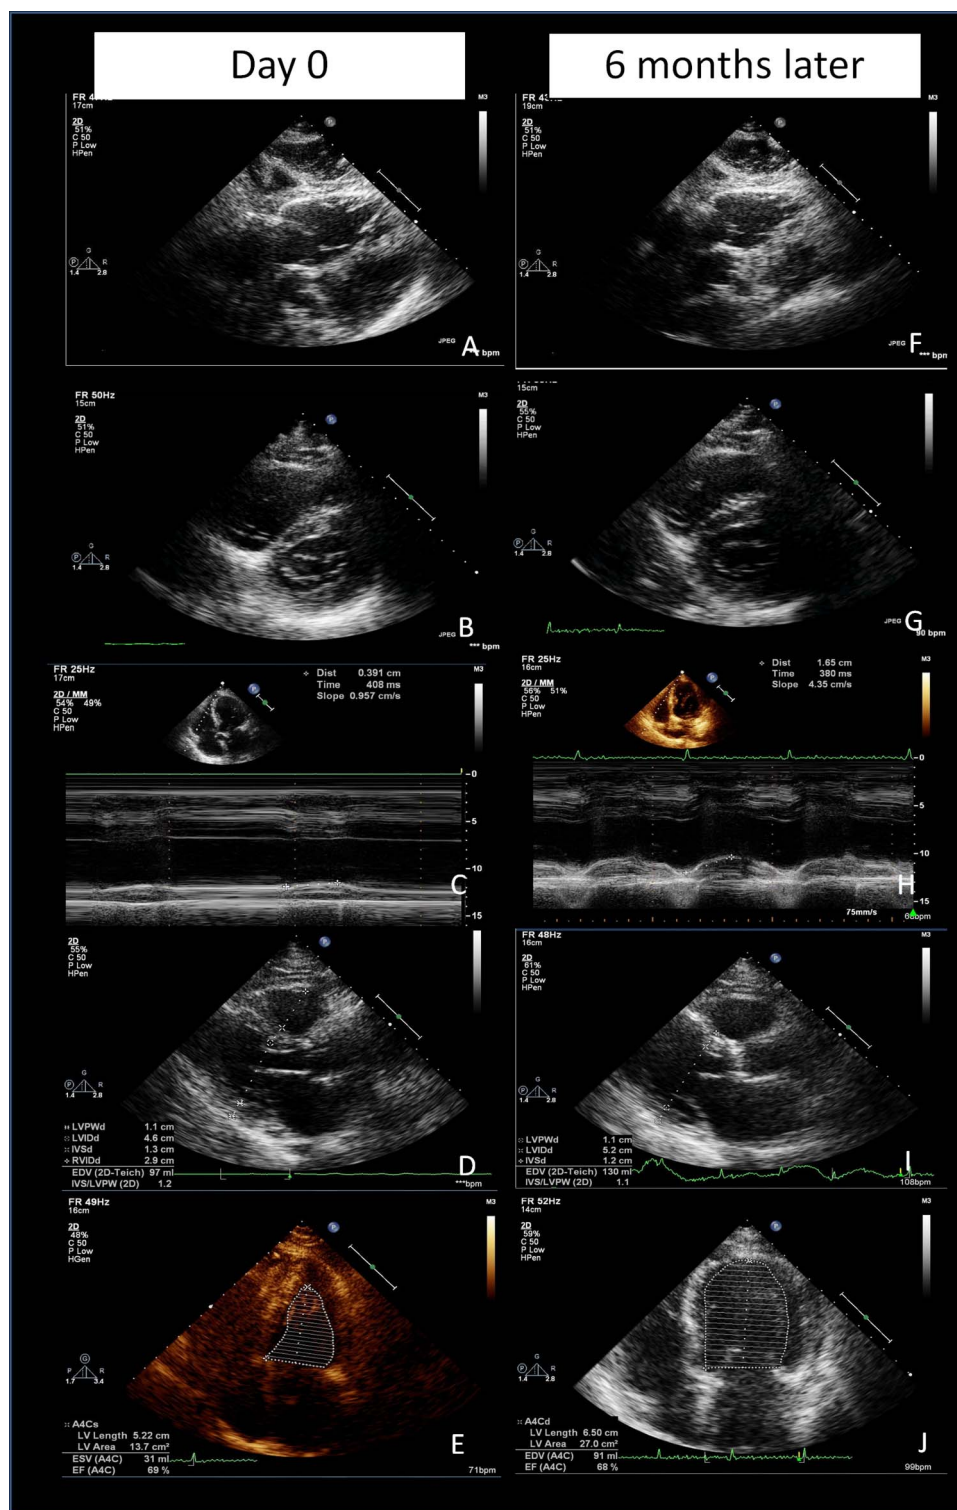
Two-dimensional transthoracic echocardiogram at admission (A–E) and 6 months later (F–J), showing recovery of right ventricle dilation and function, and normal global and segmental function of left ventricle.
